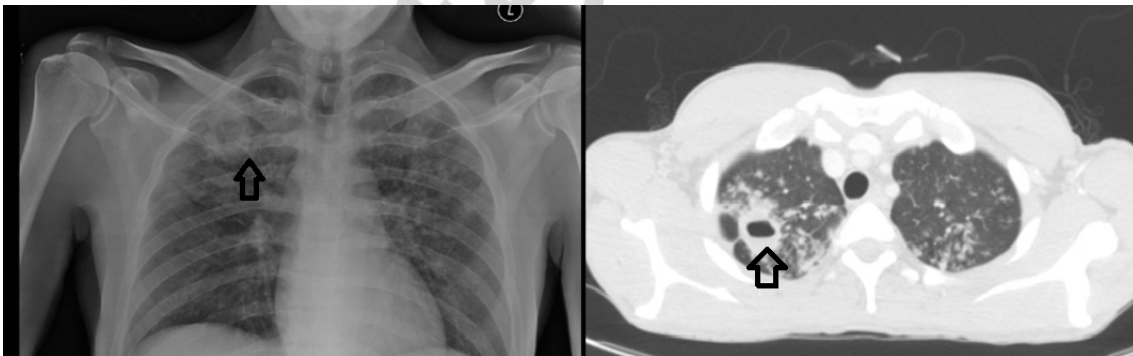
Thorax radiography and CT scan (axial section) revealing pulmonary cavitation (arrows).
